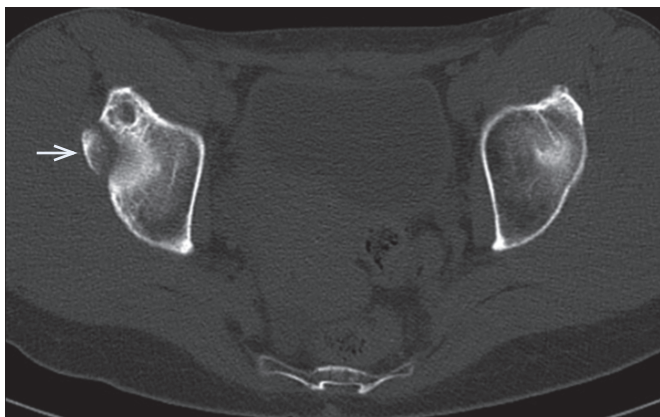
Sagittal plane CT scan image optimized for bone density, showing the “os acetabuli” (arrow).
